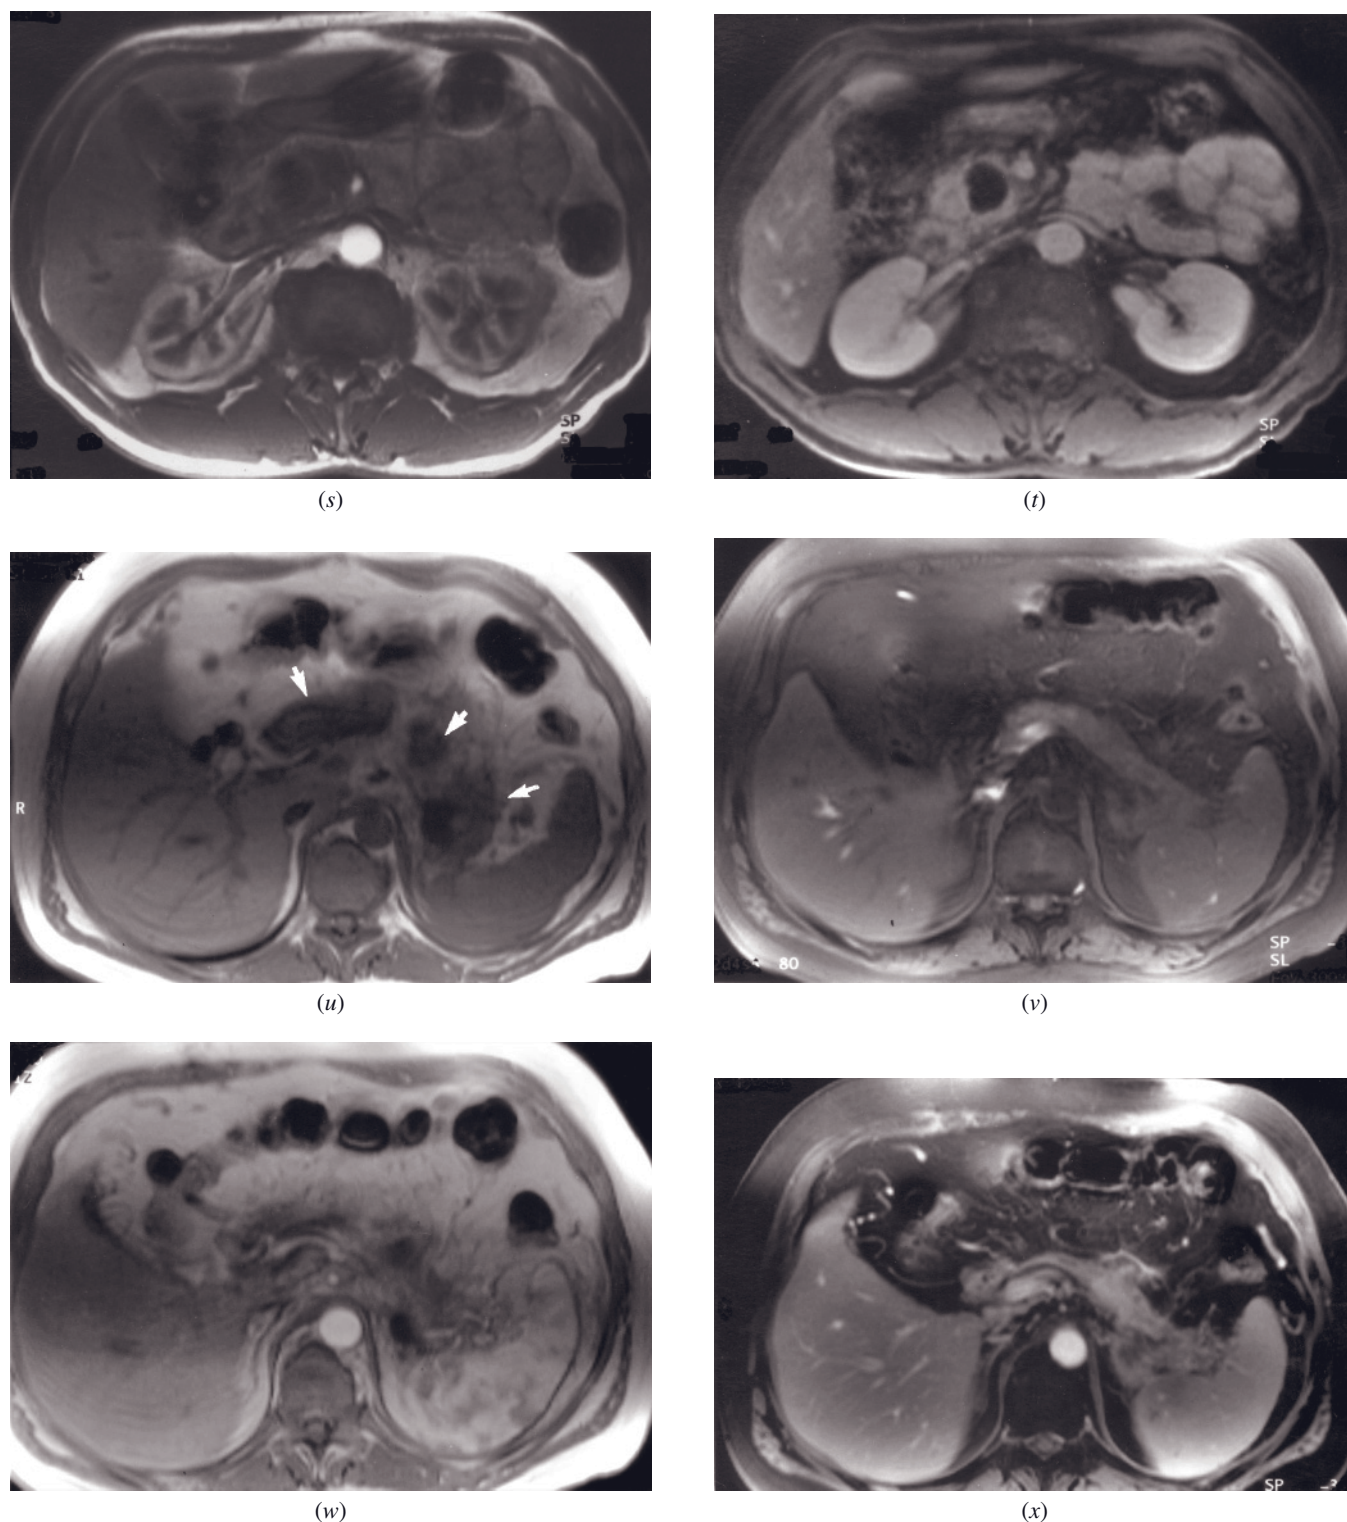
(Continued) T1-weighted SGE (s), and 90-s postgadolinium fat-suppressed SGE (t) images in a fourth patient. A pseudocyst is present in the head of the pancreas (arrow, r). Note the decreased signal on the noncontrast T1-weighted fat-suppressed SGE image (r), and minimal heterogeneous enhancement on the immediate postgadolinium SGE image (s) with progressive enhancement on the parenchyma (t), which are imaging features of chronic pancreatitis. Compare this appearance to the pseudocyst in the pancreatic head of patients with acute pancreatitis (fig. 4.77).
